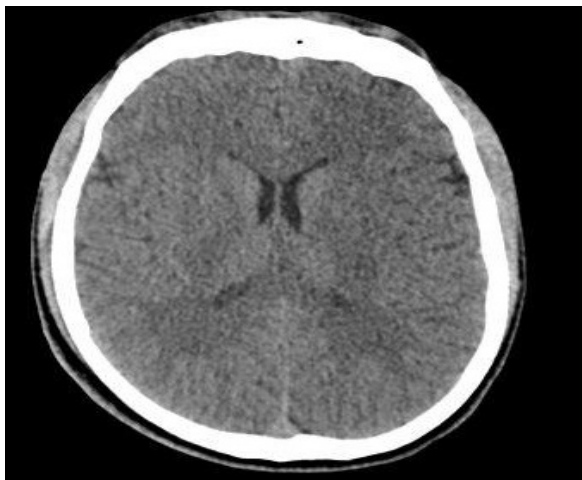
There was no distinguishable abnormality found in the axial plane non-contrast brain CT image at the level of basal ganglia.
